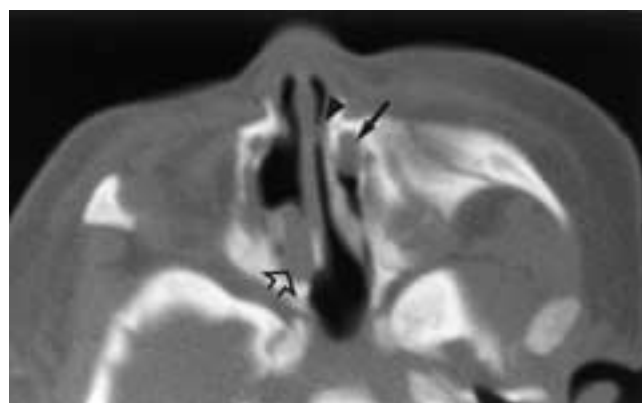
Nasal obstruction in a 2-day-old girl. Axial CT demonstrates unilateral choanal atresia (open arrow), pyriform aperture stenosis (arrowhead), and a nasolacrimal duct cyst (black arrow). Contrast these findings with those seen in Figure 29-22.
